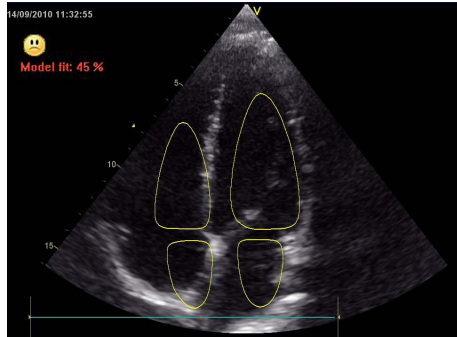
Initial fit of the apical 4-chamber view model.
